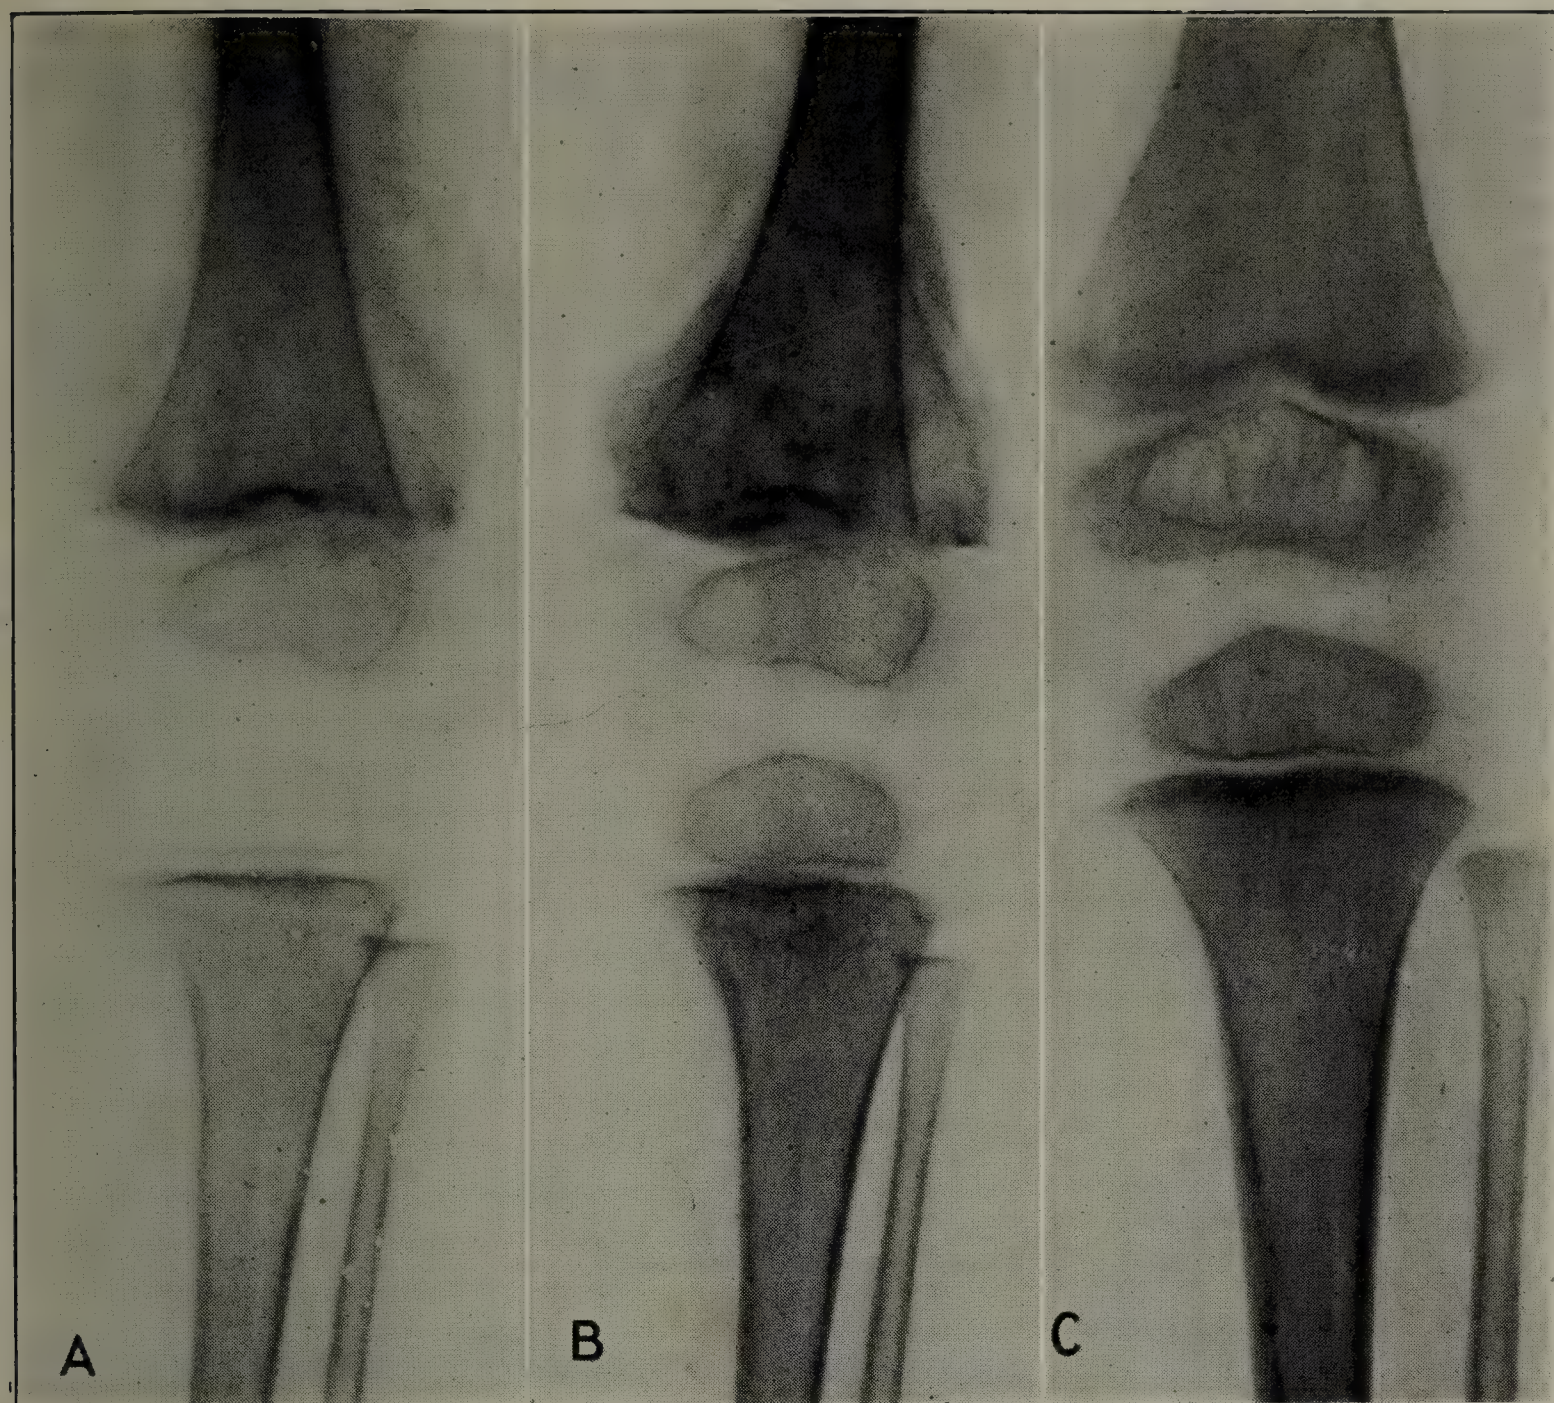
ROENTGEN-RAY CHANGES IN SCURVY.
